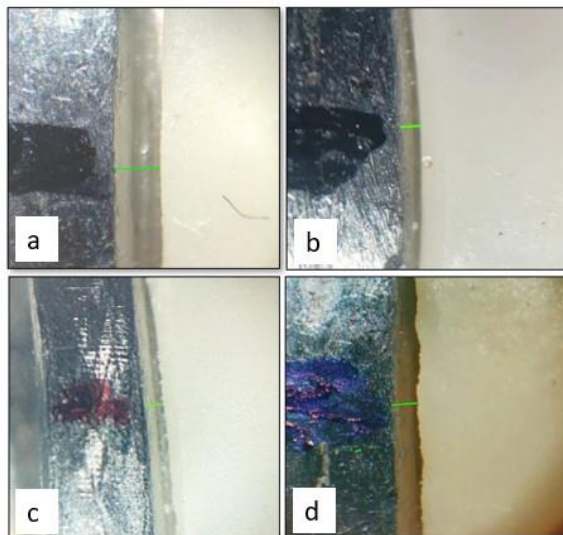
Vertical marginal discrepancy of (a) PMMA (DPI), (b) Bis-GMA (PROTEMP-4), (c) Light cure resin (REVOTEK LC) and (d) Dual cure (TEMPSMART) by indirect technique
